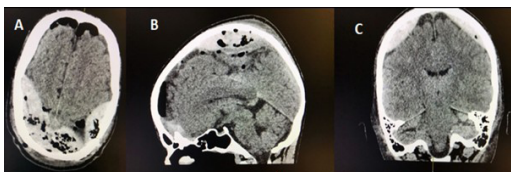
Post-operative CT Head.
